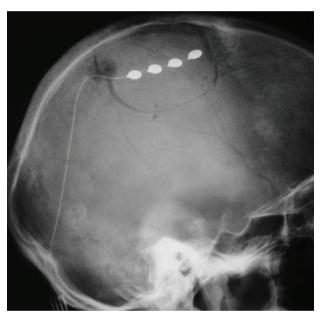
Postoperative cranial X-ray showing the position of the four electrodes.
